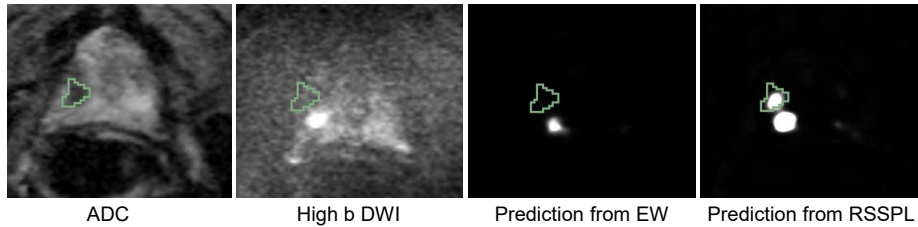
Qualitative comparison on Prostate158. The baseline model (MNet-CEF-EW) fails to detect the lesion (green circle) due to ADC–DWI misalignment, while the RSSPL-trained model (MNet-CEF-RSSPL) detects it.
